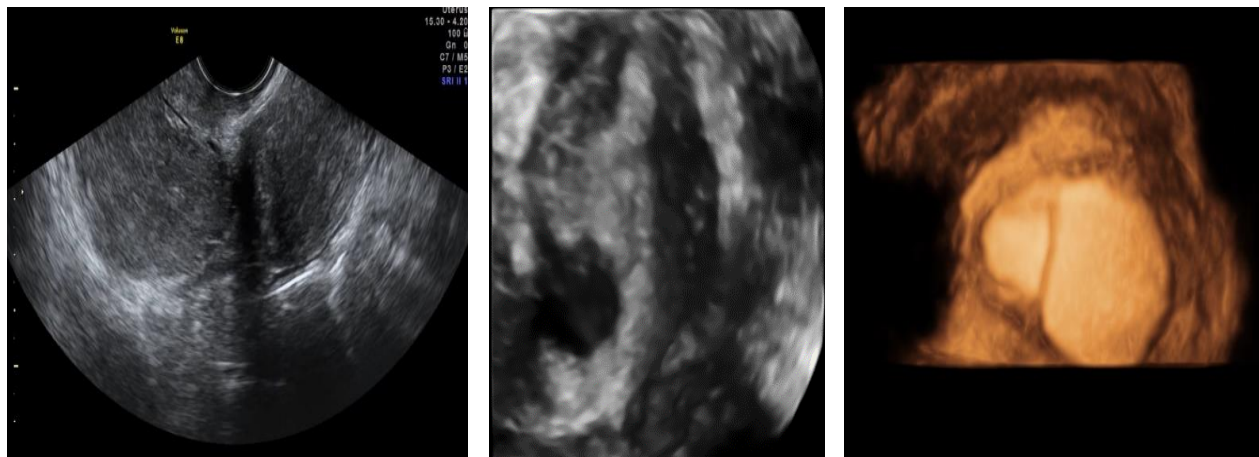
1B, 1C: Ultra sonography Findings
